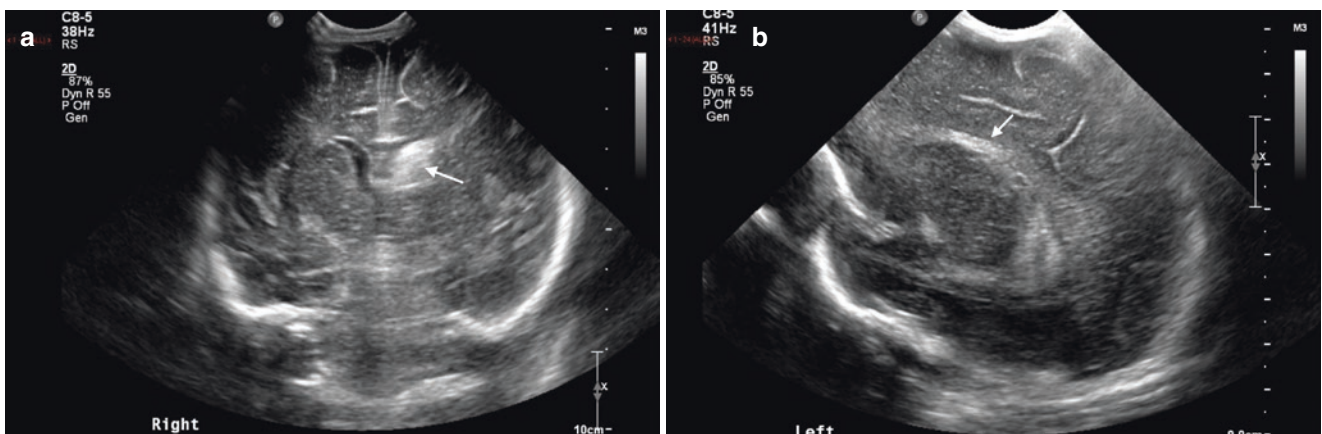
Grade 2 intraventricular haemorrhage. Coronal (a) and parasagittal (b) ultrasound images show hyperechoic haemorrhage filling the left lateral ventricle. The ventricle is not dilated
